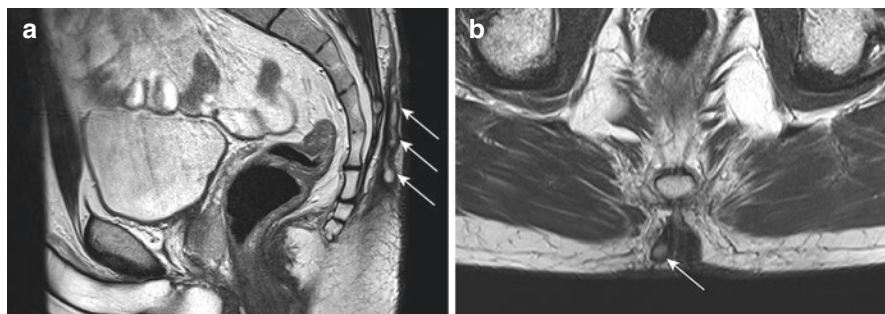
Typical location of pilonidal sinus (arrows) at a sagittal T2-weighted sequence (a) and oblique axial T2-weighted sequence (b)
